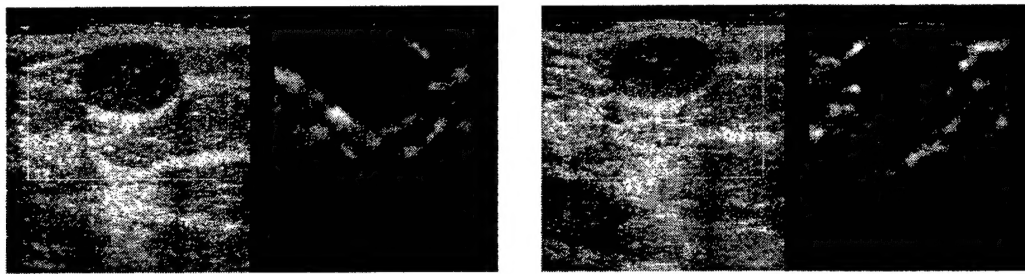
B-mode and strain images of a typical fibroadenoma at two different amounts of deformation (preload). For both elasticity images the average strain in the image is about 1.2%. The image pair on the left was acquired with the ultrasound transducer just barely in contact with the skin surface. At low preload fibroadenomas typically are stiff compared to their surrounding glandular tissue. As the preload increases the strain image contrast of the fibroadenoma decreases and the lesion becomes nearly equal stiffness compared to the surrounding tissue.
